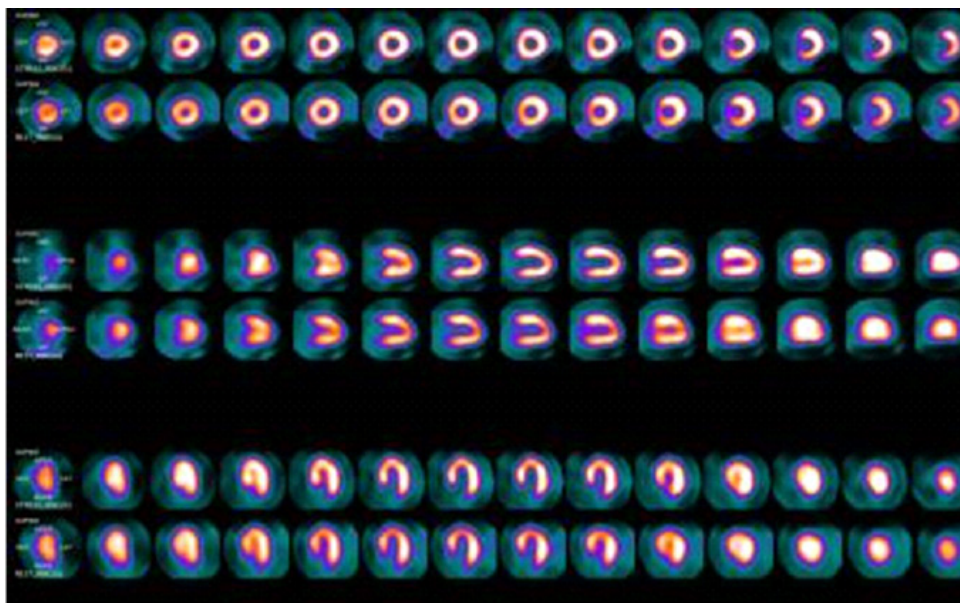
Case 1 - Myocardial perfusion scintigraphy within normality. Images acquired with dedicated cardiac equipment (gamma camera), equipped with solid cadmium-zinc-tellurium detectors.
